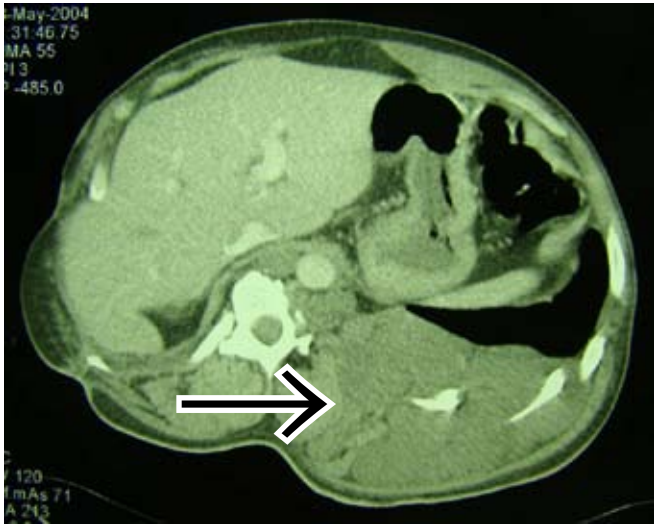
CT scan of the preceding patient showing a large plexiform neurofibroma on the left side, causing spine and rib changes.
